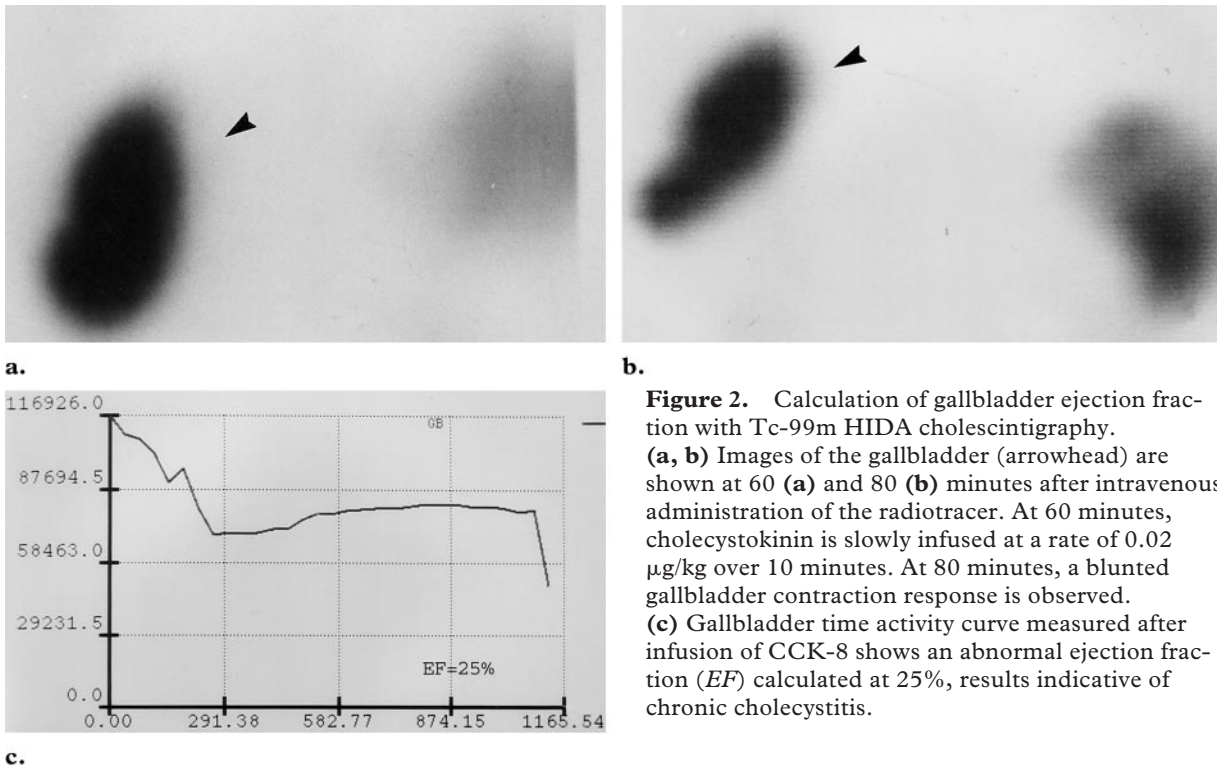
Calculation of gallbladder ejection fraction with Tc-99m HIDA cholescintigraphy. (a, b) Images of the gallbladder (arrowhead) are shown at 60 (a) and 80 (b) minutes after intravenous administration of the radiotracer. At 60 minutes, cholecystokinin is slowly infused at a rate of 0.02 $\mu\text{g}/\text{kg}$ over 10 minutes. At 80 minutes, a blunted gallbladder contraction response is observed. (c) Gallbladder time activity curve measured after infusion of CCK-8 shows an abnormal ejection fraction (EF) calculated at 25%, results indicative of chronic cholecystitis.
